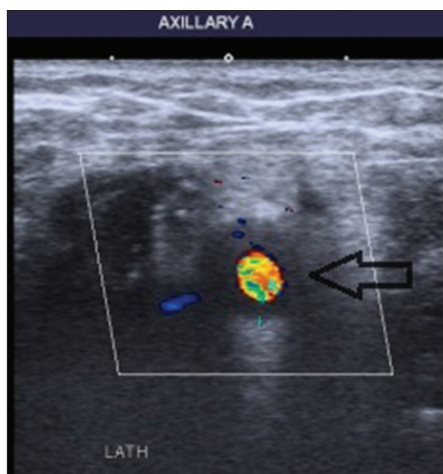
Halo sign on axillary artery ultrasound
